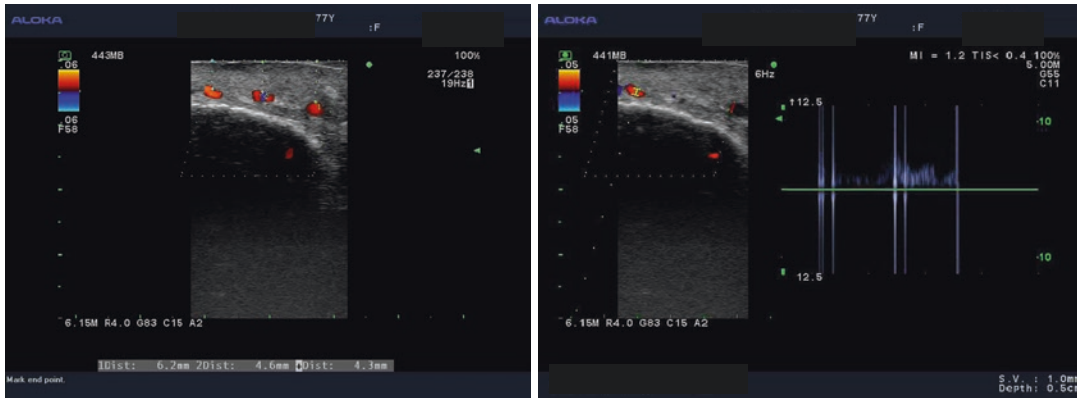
Typical duplex ultrasonic examination. Flow patterns and localization of the lesions are depicted (*left*); flow intensity and pulse are demonstrated (*right*)
